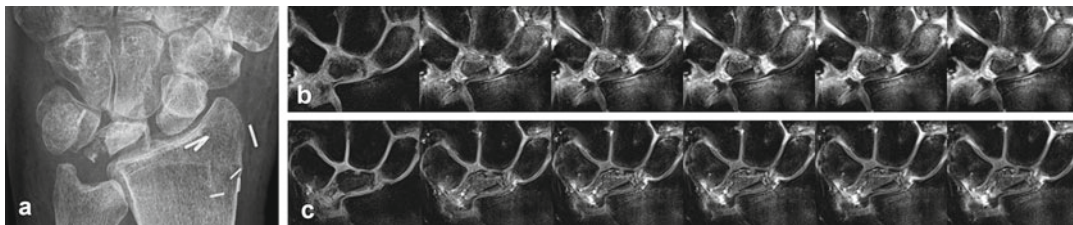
Dynamic perfusion MRI in stage IIIb of Kienböck's disease in the follow-up after free-vascularized osteochondral bone grafting. Patient is a 30-year-old female with advanced Kienböck's disease following vascularized bone grafting of the diseased lunate. (a, b) Dorsopalmar radiograph and MRI perfusion study (coronal 3D fast GRE sequence every 20 s after gadolinium injection) 4 months after grafting and hardware removal
